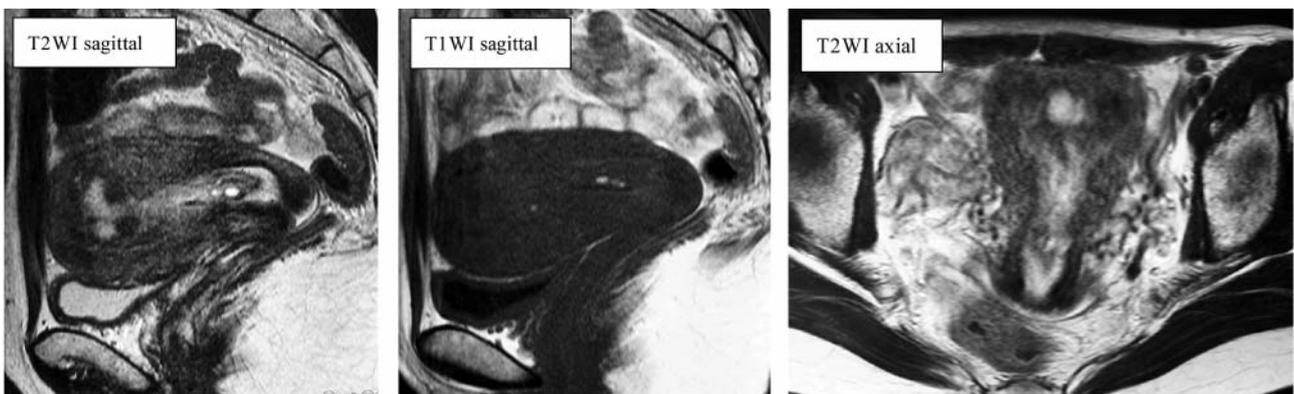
Magnetic resonance imaging demonstrating a mass to be a polypoid tumor in the intrauterine cavity. The tumor has small cysts at the lower pole, and seems to be continuous with the previously detected fundus tumor.
